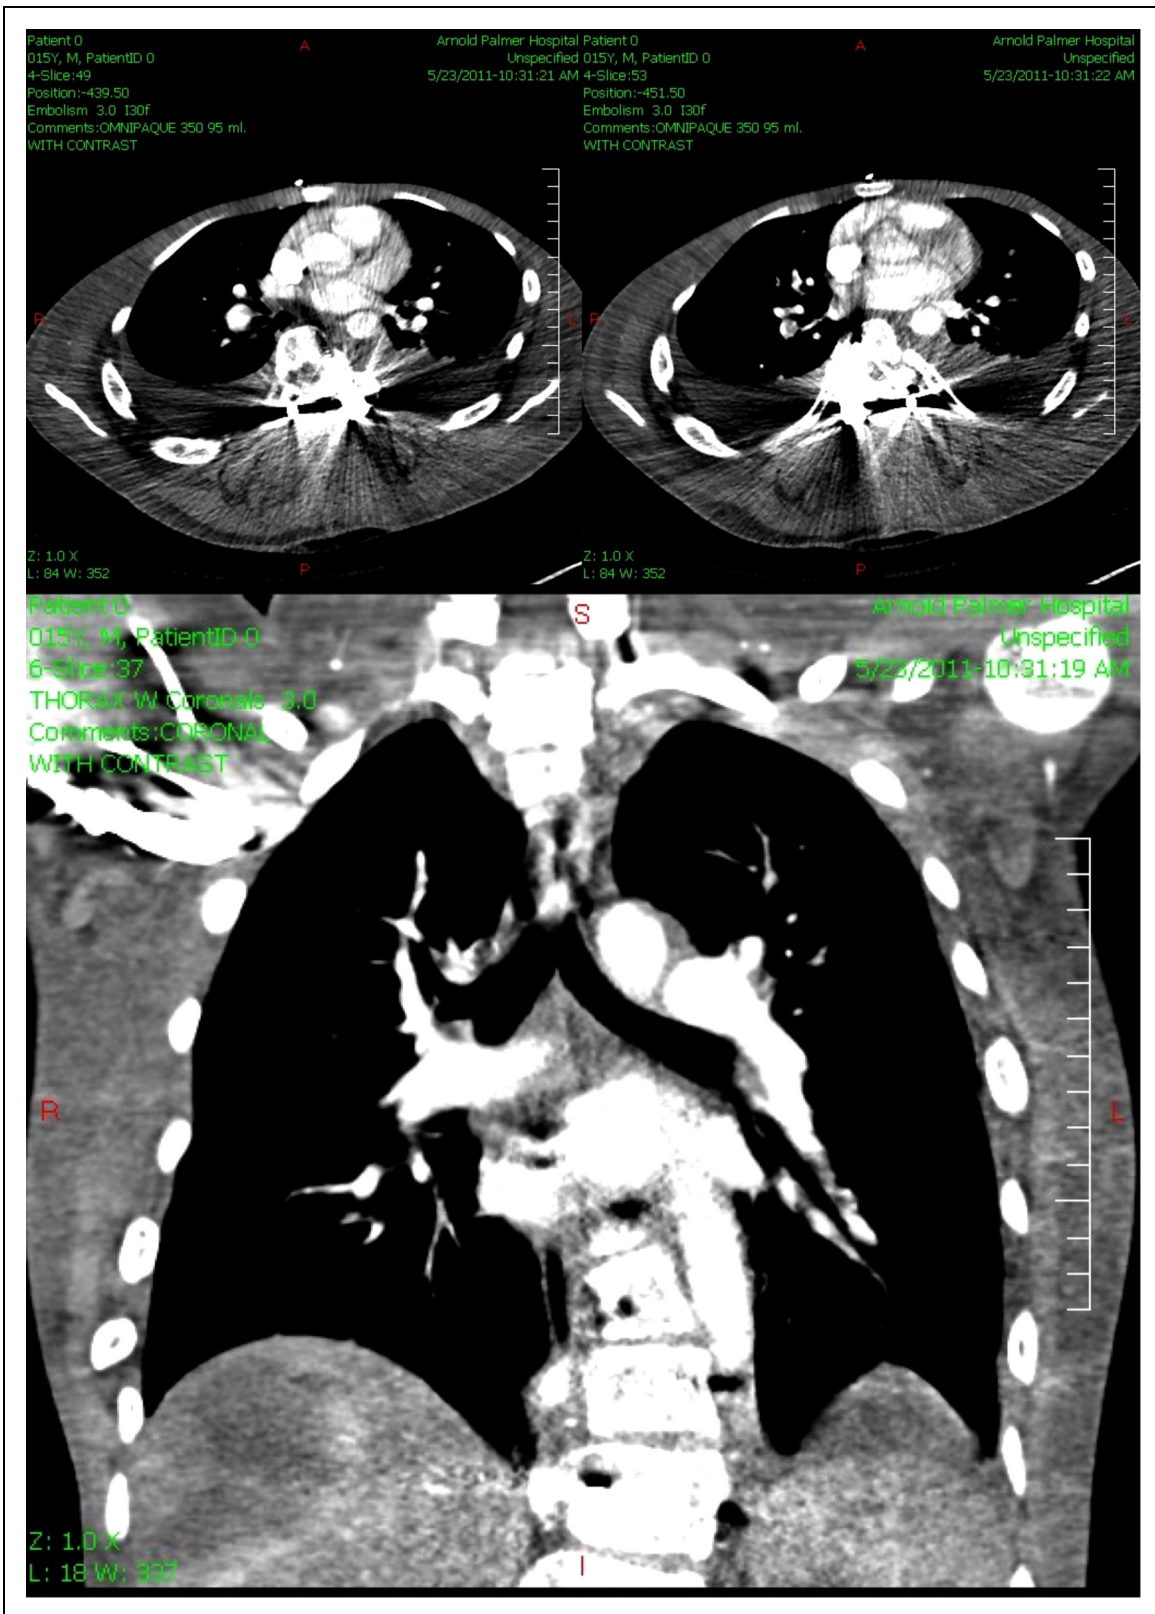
Transverse and vertical sections of CT Angiography represent the complete resolution of pulmonary embolism.
